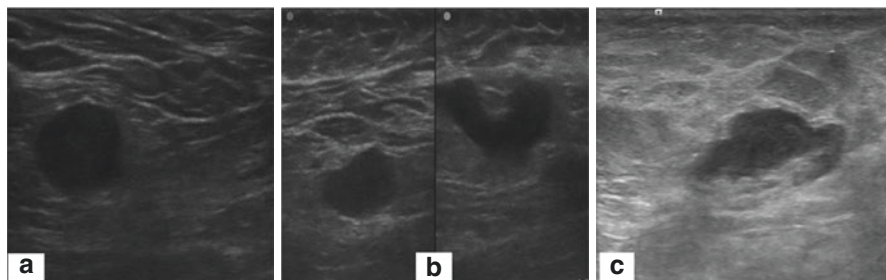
Suspicious axillary lymph nodes: Ultrasound features raising suspicion of metastatic/involved axillary lymph nodes in patients with known breast cancer include- (a) loss of fatty hilum, (b) asymmetrical cortical thickening and (c) Focal cortical thickening
